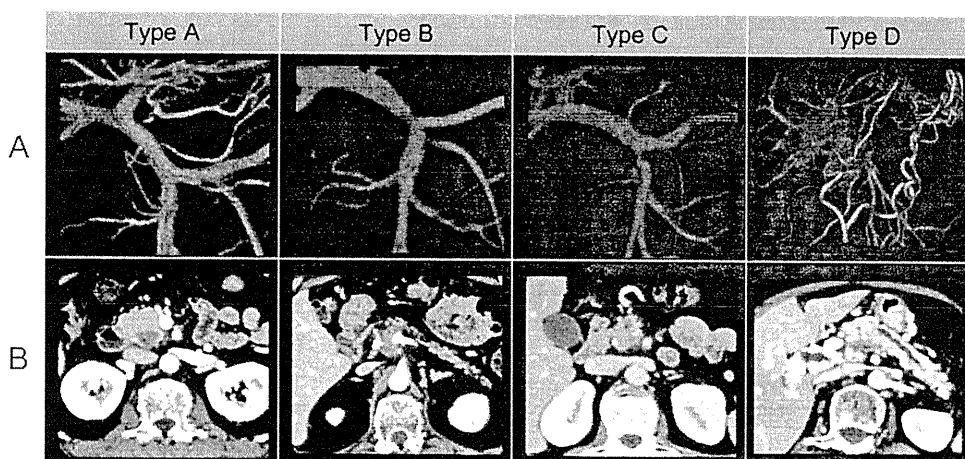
Radiographic classification of PV invasion by A, portography and B, CT.
